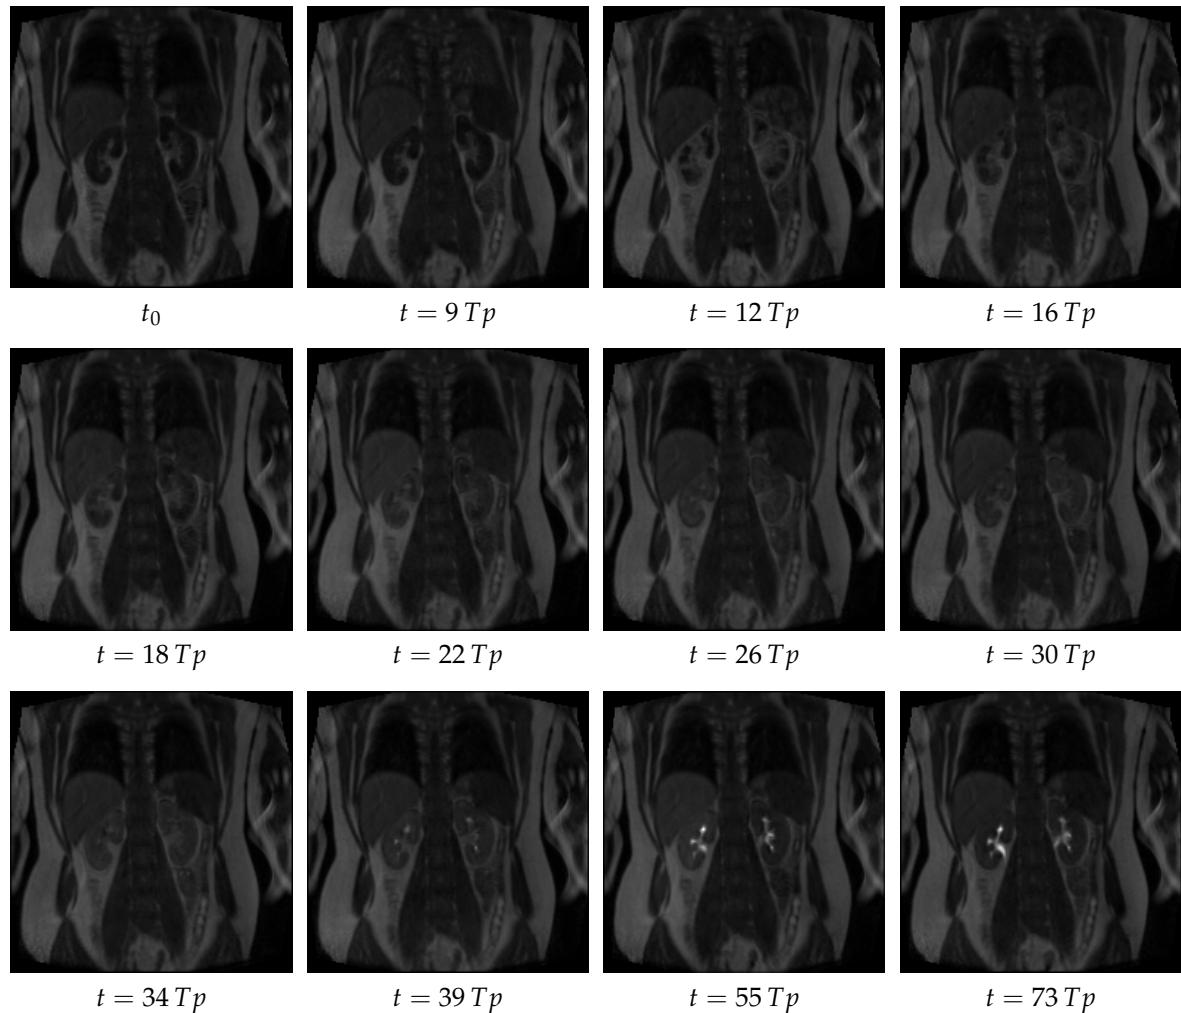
Sample DCE-MRI sequence of the healthy kidneys. Tp is a given time point. Firstly, the signal enhancement is observed in the renal cortex. Then, the tracer travels to the renal medulla and finally is collected by the collecting system.
